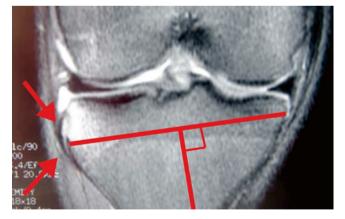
MRI showing anterolateral capsular structures (arrows)
